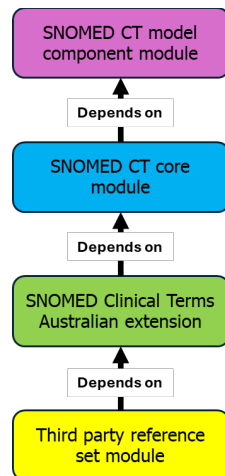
SNOMED CT AU module dependency as of November 2014
